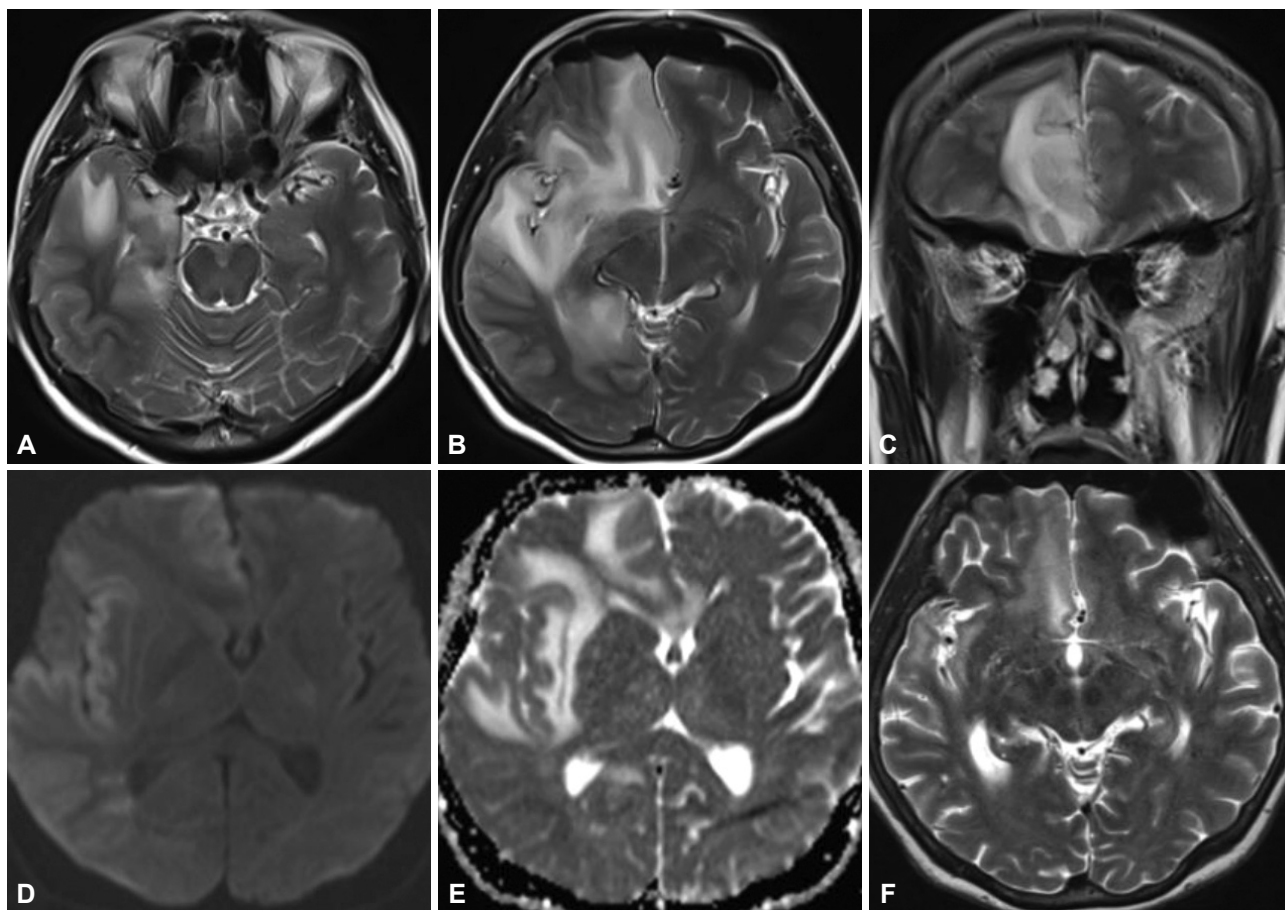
MRI of the brain at presentation demonstrated multifocal cortical and subcortical white matter T2 hyperintensity in the right hippocampus and right middle and superior temporal gyri (A and B), both cingulate gyri (R > L), the right superior frontal and rectus gyri (B and C) and the right insular cortex (B), with mild restricted diffusion of the cortex and T2 shine-through within the subcortical white matter on DWI (D) and the corresponding ADC map (E), without hemorrhage (not shown) or postcontrast enhancement (not shown). Follow-up MRI 6 weeks later demonstrated decreased T2 hyperintensity in the cortex and subcortical white matter of the original lesions (F).
